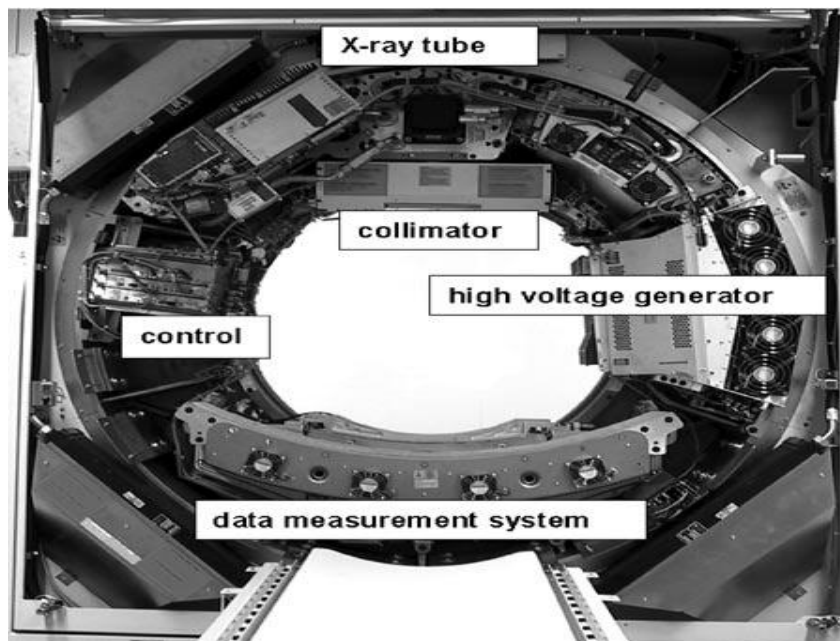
Major Internal Components of CT gantry
